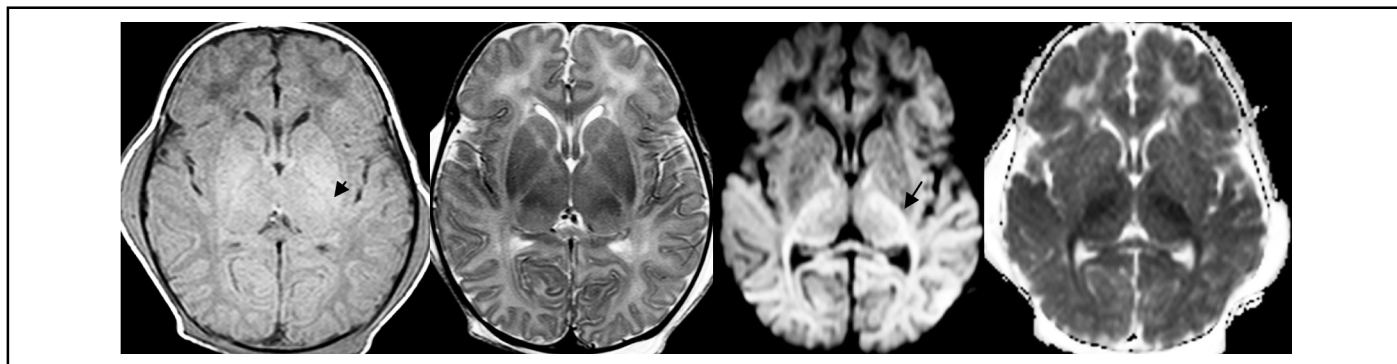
T1,T2,DWI and ADC show hypoxic ischemic encephalopathy changes - loss of the T1 hyperintense myelinated posterior limb of internal capsule with diffusion restriction.
